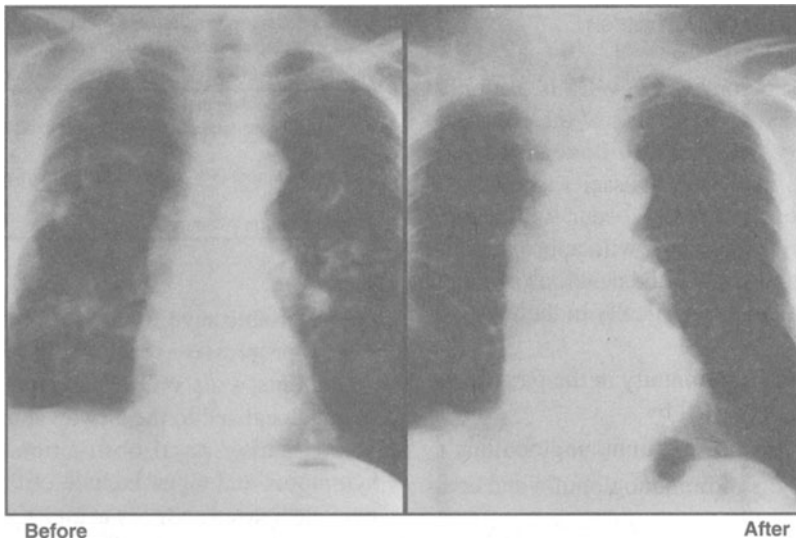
Chest x-rays of a patient with Wegener's granulomatosis before and after treatment. Before: bilateral nodular infiltrates with cavitation in middle and upper lung fields. After: the same patient showing almost complete resolution of abnormalities after 2 months of treatment.
